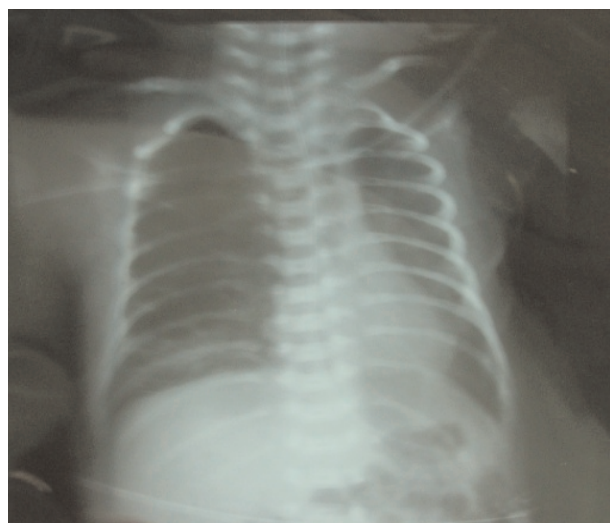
Controlled chest radiography: heterogeneous opacity in the lower lobe of the right lung.
